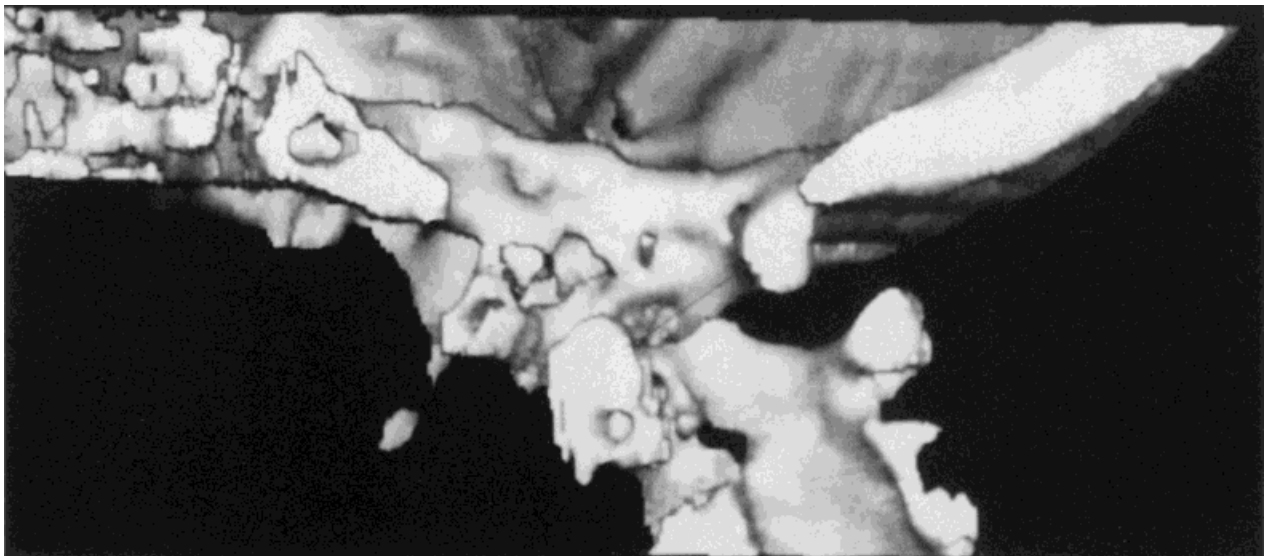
Same patient as in Figure 7. CT reconstruction reveals the odontoid hypoplasia with an Os odontoideum. The measurement of the anterior-posterior cervical spine dimension and posterior dislocation of C<sub>2</sub> is apparent.
